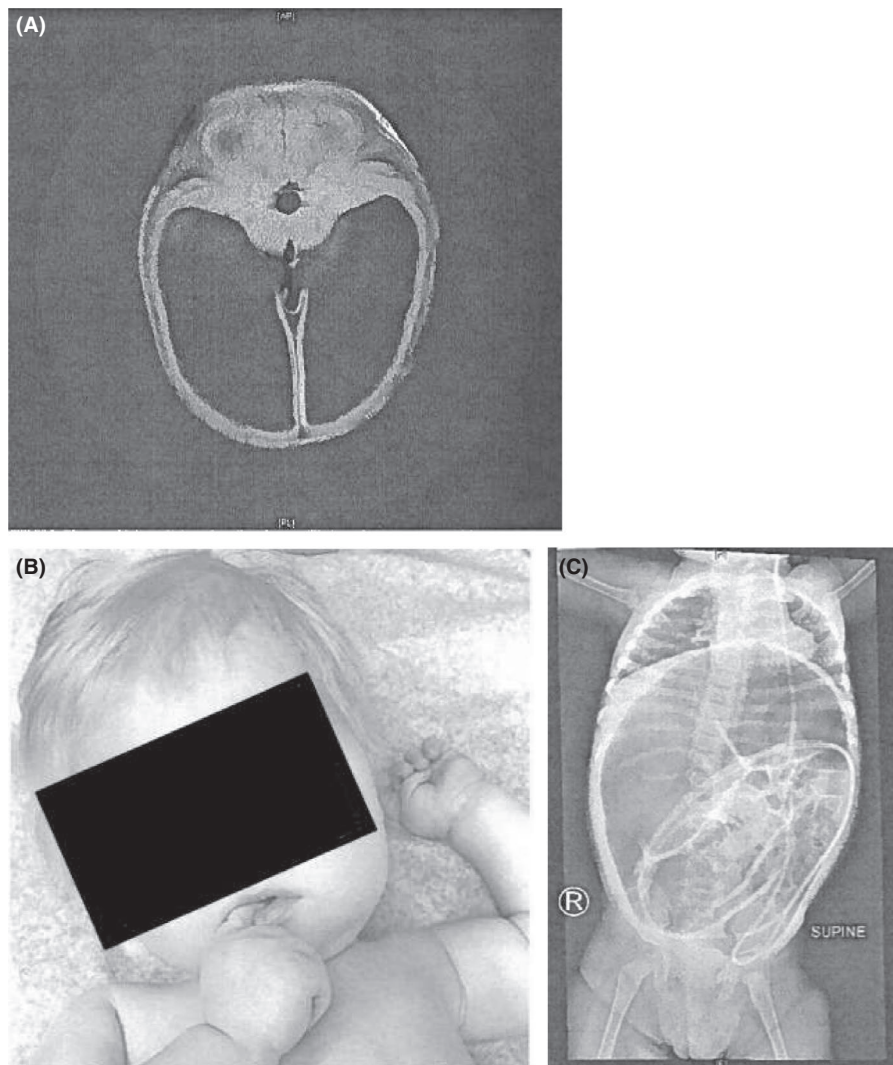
Clinical and diagnostic imaging characteristics of L1 Syndrome. A, Magnetic resonance imaging of head with ventriculomegaly and absent corpus callosum. B, Bilaterally adducted thumbs. C, Abdominal radiograph with dilated loops, characteristic of HD
